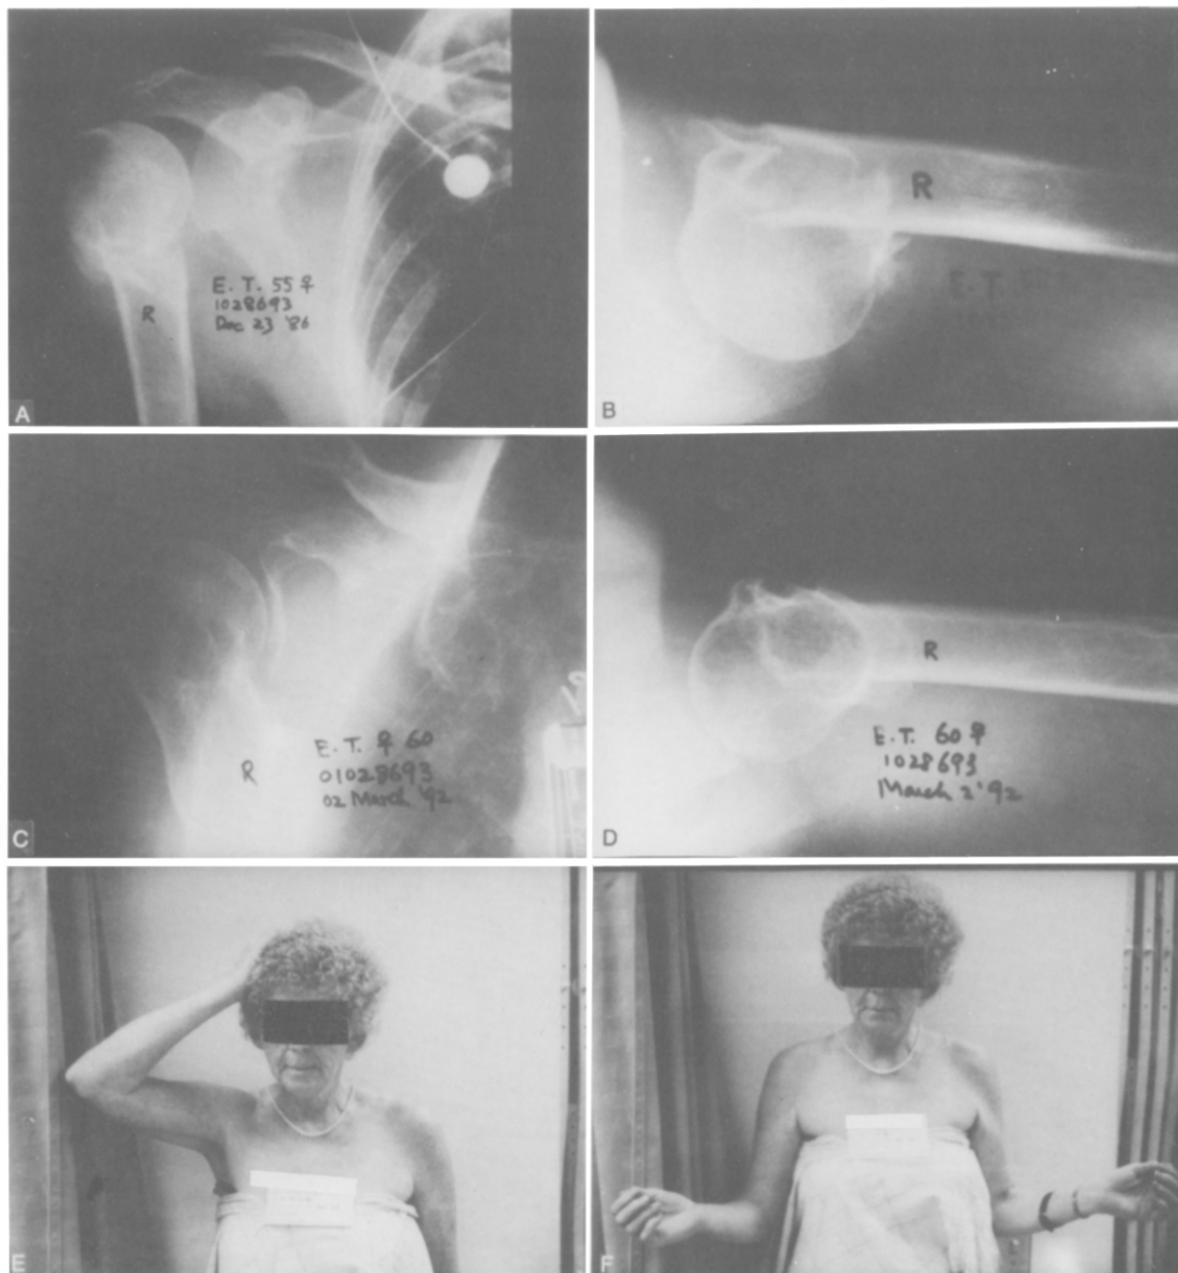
Fifty-five-year-old woman injured by motor vehicle accident. Skeletal traction was applied after failure of closed reduction. A and B, Initial anteroposterior and lateral radiographs show surgical neck fracture with medial displacement and anterior angulation. C and D, Anteroposterior and lateral radiographs made 5 years later demonstrate union with good alignment. E and F, Photographs taken 5 years after injury reveal good range of motion, with score of 73 points.
